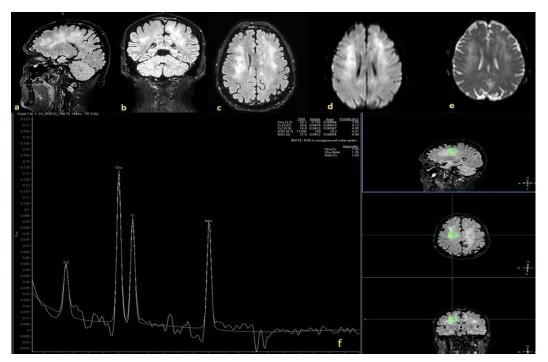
Imaging of Lymphomatosis cerebri. Sagittal (a), coronal (b), and axial (c) FLAIR images of the brain showing diffuse high signal intensity involving deep and juxtacortical white matter, basal ganglia, dentate nuclei and cerebellar medulla. DWI (d) and ADC (e) images showing reduced water diffusivity in the same affected regions, thus suggesting high cellularity. ¹H-MRS disclosing high Cho/NAA and Cho/Cr ratio indicating enhanced cell membrane turnover and reduced neuronal viability (f).
